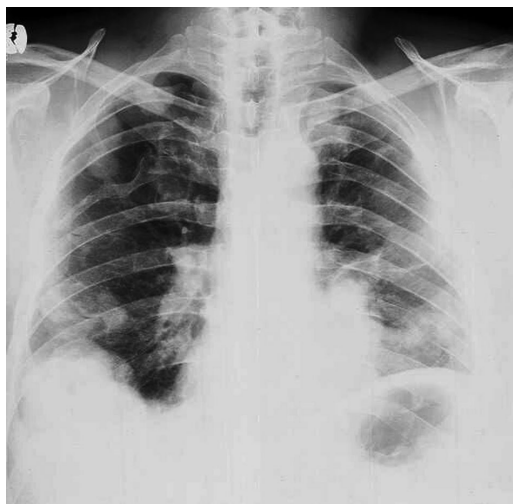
Multiple nodular infiltrates of the lung on chest radiography.
